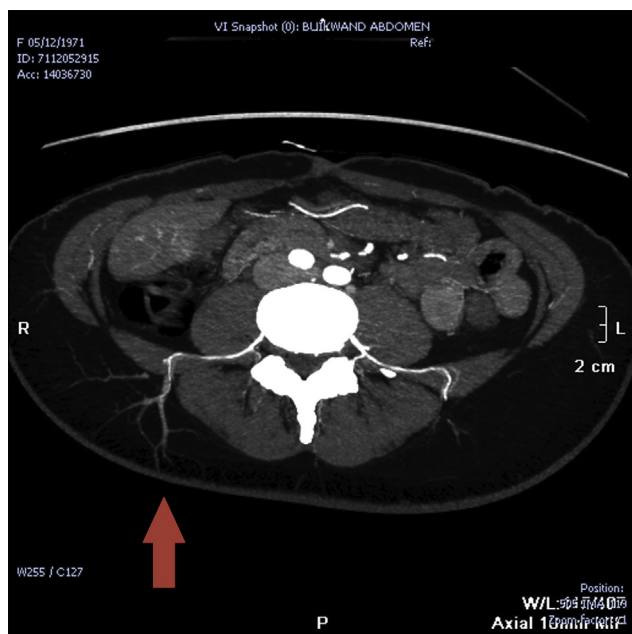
Classic CT angiography of a perforator of the fourth lumbar artery (arrow).
